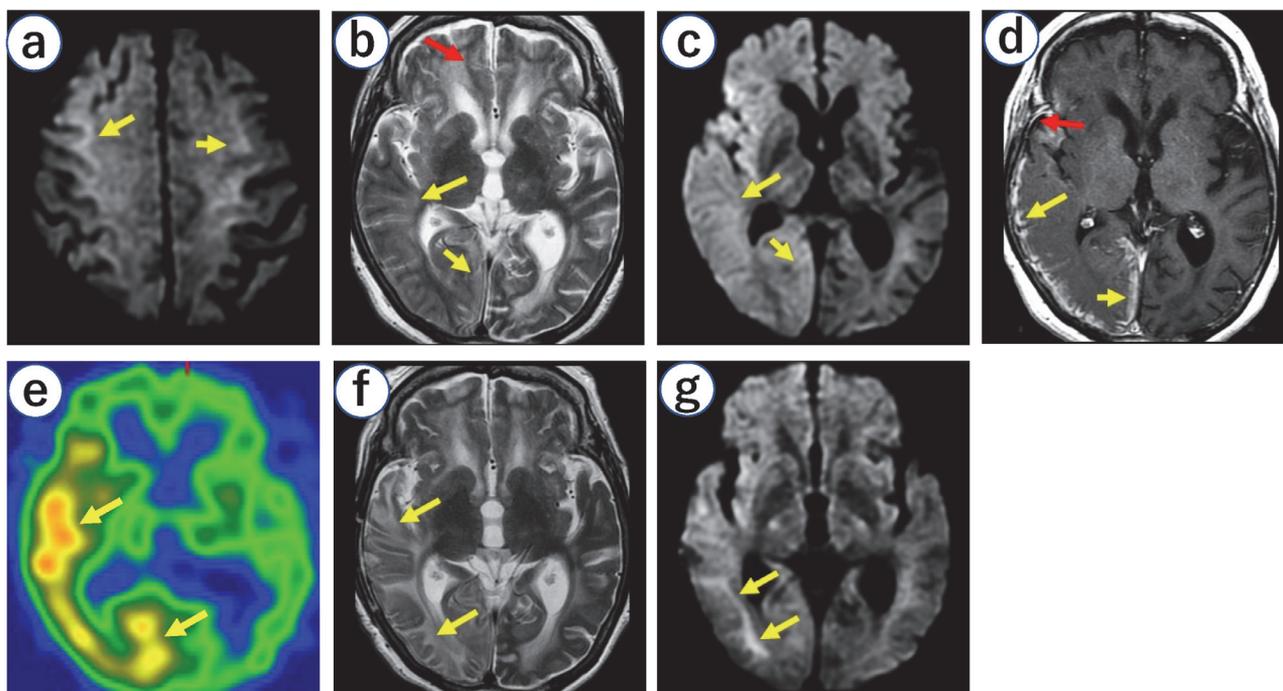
Magnetic resonance imaging. (A) Diffusion weighted images (DWI) images obtained at admission shows hyperintense lesions in the corticomedullary junctions (CMJs) of both frontoparietal lobes (yellow arrows). T2-weighted imaging (T2WI) (B) and DWI (C) obtained on day 15 of admission demonstrate swelling and hyperintensities in the cortices of the right temporal and occipital lobes (yellow arrows). The cortical sulci are effaced. Hyperintense lesions are seen bilaterally in the deep frontal white matter on T2WI (red arrows). Magnetic resonance angiogram demonstrates dilatation of the right middle cerebral artery and posterior cerebral artery (not shown). (D) T1-weighted image after administration of contrast medium shows cortical enhancement in the right temporal and occipital lobes (yellow arrows). Abnormal enhancement is mainly observed in the gyral crowns but absent or only slightly observed in the bottoms of sulci (crown enhancement). Abnormal enhancement is also seen in the dura mater adjacent to the cortices (red arrow). (E) SPECT image shows hyperperfusion in the right temporal and occipital lobes (yellow arrows). T2WI (F) and DWI (G) obtained on day 45 of admission show hyperintense lesions in the CMJs of the right temporal and occipital lobes (yellow arrows). Subcortical hyperintense lesions are also observed on T2WI but not in the cortices of the same areas. T2WI obtained 10 months later shows focal atrophy. Hyperintense lesions in the CMJs disappeared in the right temporal and occipital lobes as observed on DWI (not shown).
